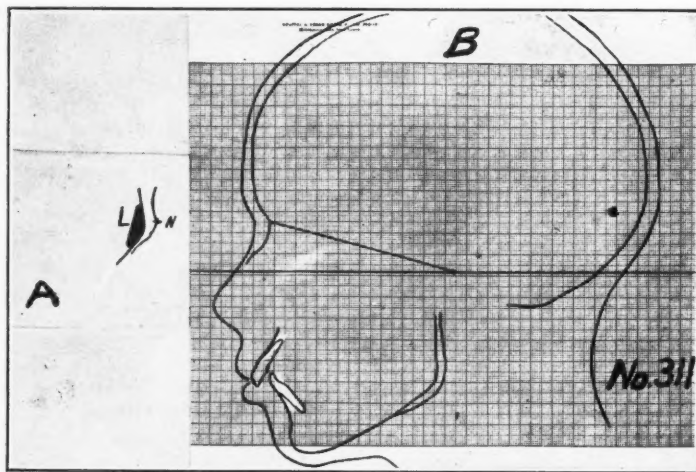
A, Outline of nasion area obtained from nasion area x-ray or profile x-ray picture. L, nasion locator; N, nasion of skull. B, Outline obtained from profile x-ray picture of Case 311 (see Fig. 11).
